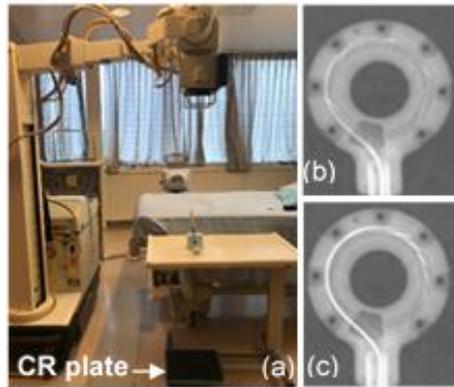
(a) Setup used to image source dwell positions in the ring applicators using a portable x-ray machine and CR plate; 26 mm ring with (b) 6 dwell image at 15 mm separation, and (c) 5 dwell image at 5 mm separation.
